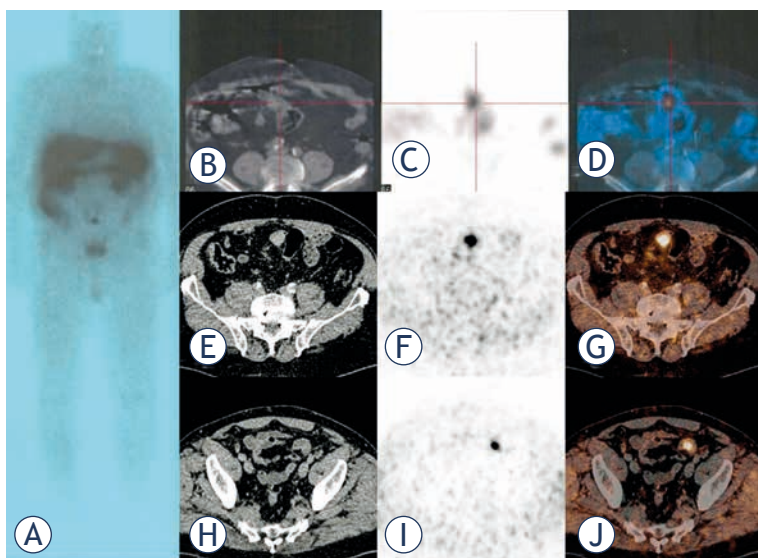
(A) In-111 DTPA octreotide detected one suspicious lesion located in the ileum (B-D) in a patient with NET liver metastases. Ga-68 DOTATOC PET/CT confirmed the lesion (E-G), but could visualise also an additional lesion in the ileum undetected by In-111 DTPA octreotide (H-J).
